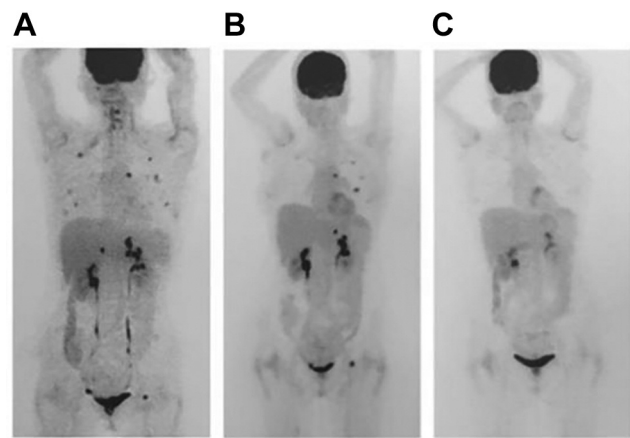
Positron-emission tomography–computed tomography at 3.5 (A) and 5 (B) months after the CD19-directed chimeric antigen receptor T-cell infusion and after the fourth cycle of pembrolizumab therapy (C).
